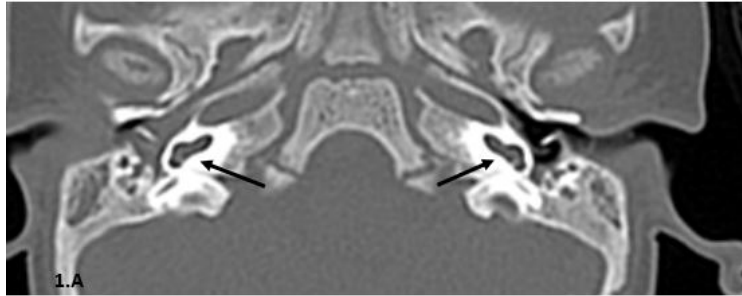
A: Axial CT bone window revealed bilateral normal basal cochlear turns (black arrows).
